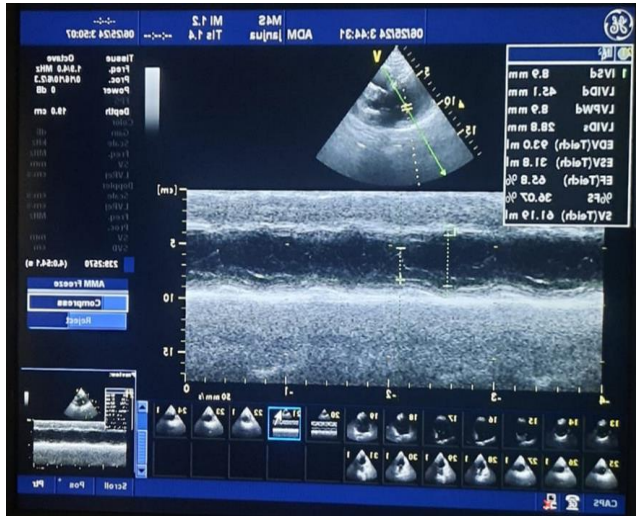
The echocardiography showing LV dimensions after one month of treatment.
